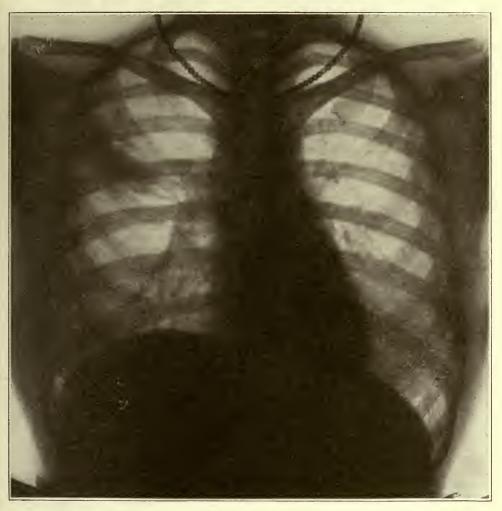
Roentgenogram of same patient as shown in Fig. 2, made after fifth weekly bronchoscopic treatment. This plate shows only a very small amount of exudate in the parenchymal portion of the right upper lobe, along the interlobar pleura. The abscess cavity is well drained. At last bronchoscopy, after 17 bronchoscopies, the bronchi were found to be free from pus. Physical examination of chest revealed nothing abnormal. Patient treated by Drs. R. M. Lukens and W. F. Moore at the Bronchoscopic Clinic, Department for Diseases of the Chest, Jefferson Hospital.
